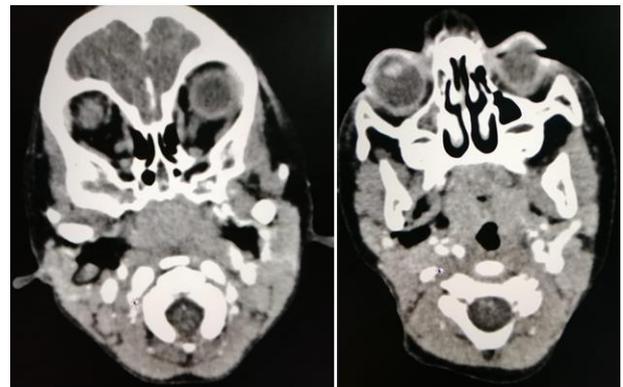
Head and neck CT scan showing the relationship of the foreign body with the neighboring anatomical structures
